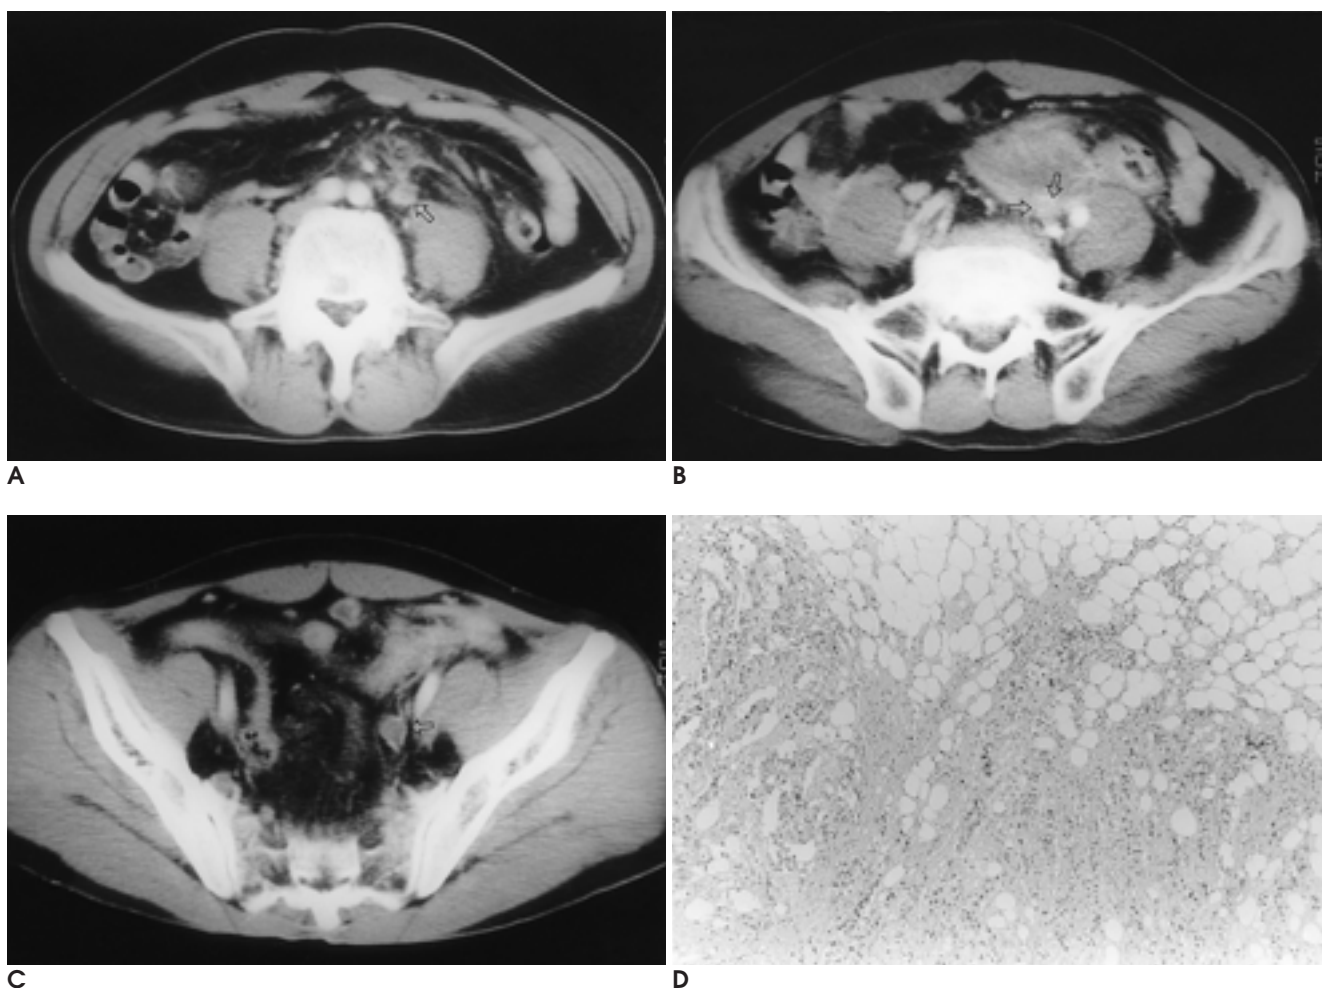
Retroperitoneal mass due to exophytic growth of eccentric ureteral transitional cell carcinoma in a 55-year-old man. (A-C); Arterial phase of spiral CT.
